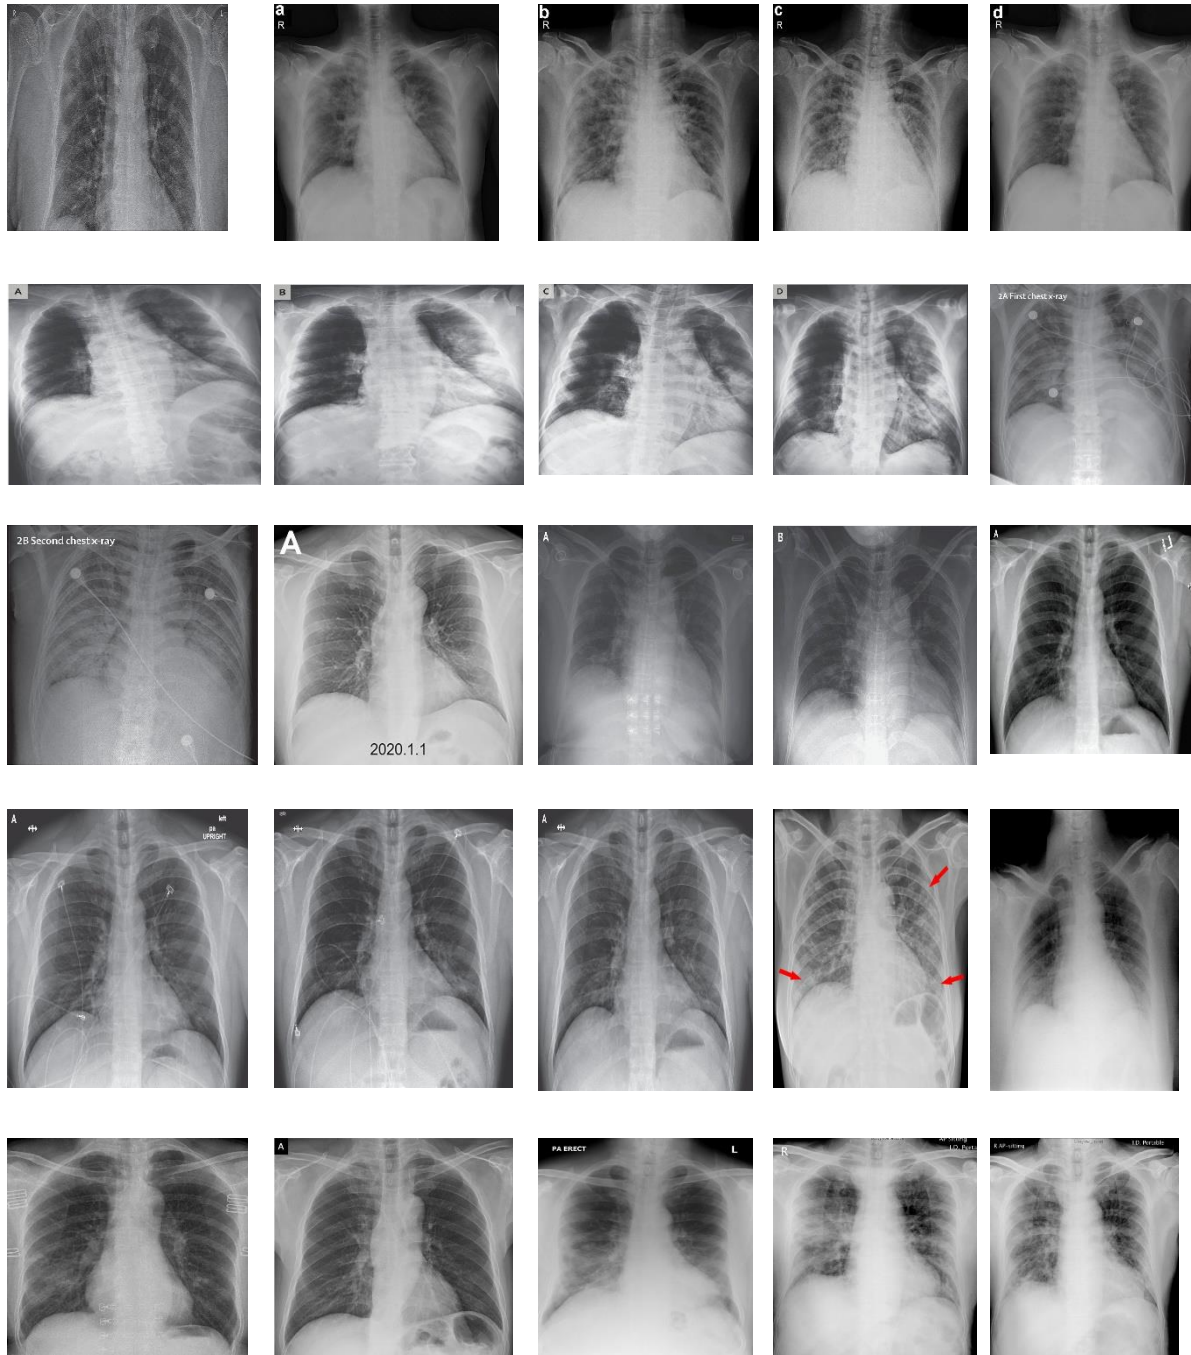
X-ray images of COVID-19+ ignoring MERS, SARS, and ARDS.
